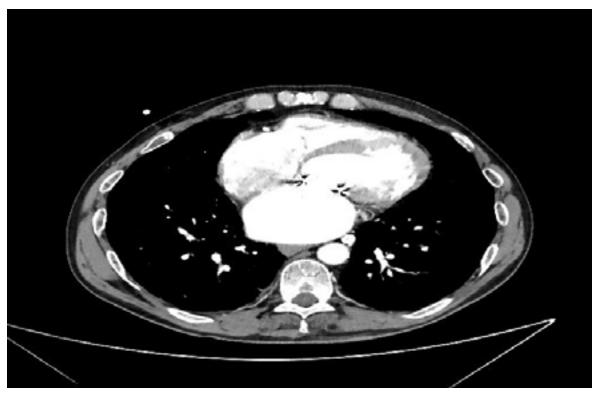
After 14 days control: Thoracic aorta CT angiography revealing complete disappearance of the large atrial thrombus in the left atrium
